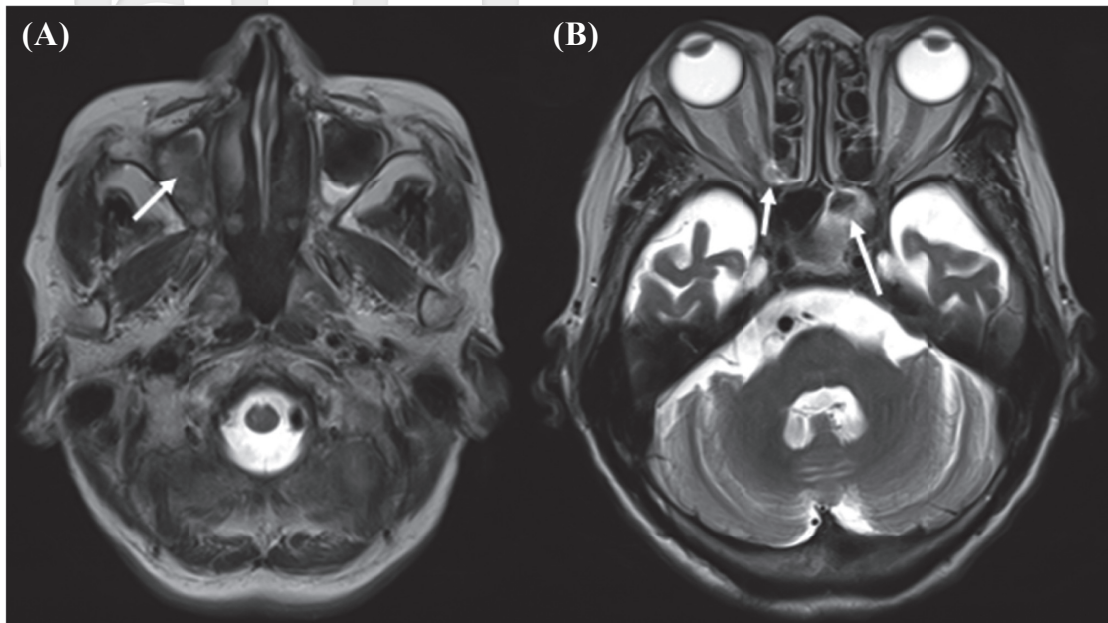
(A) Magnetic resonance imaging shows a hypointense lesion with peripheral enhancement in the right maxillary (arrow), (B) the left sphenoid sinus (long arrow), and the right ethmoid sinus with the right inferior rectus muscle compression (short arrow).
